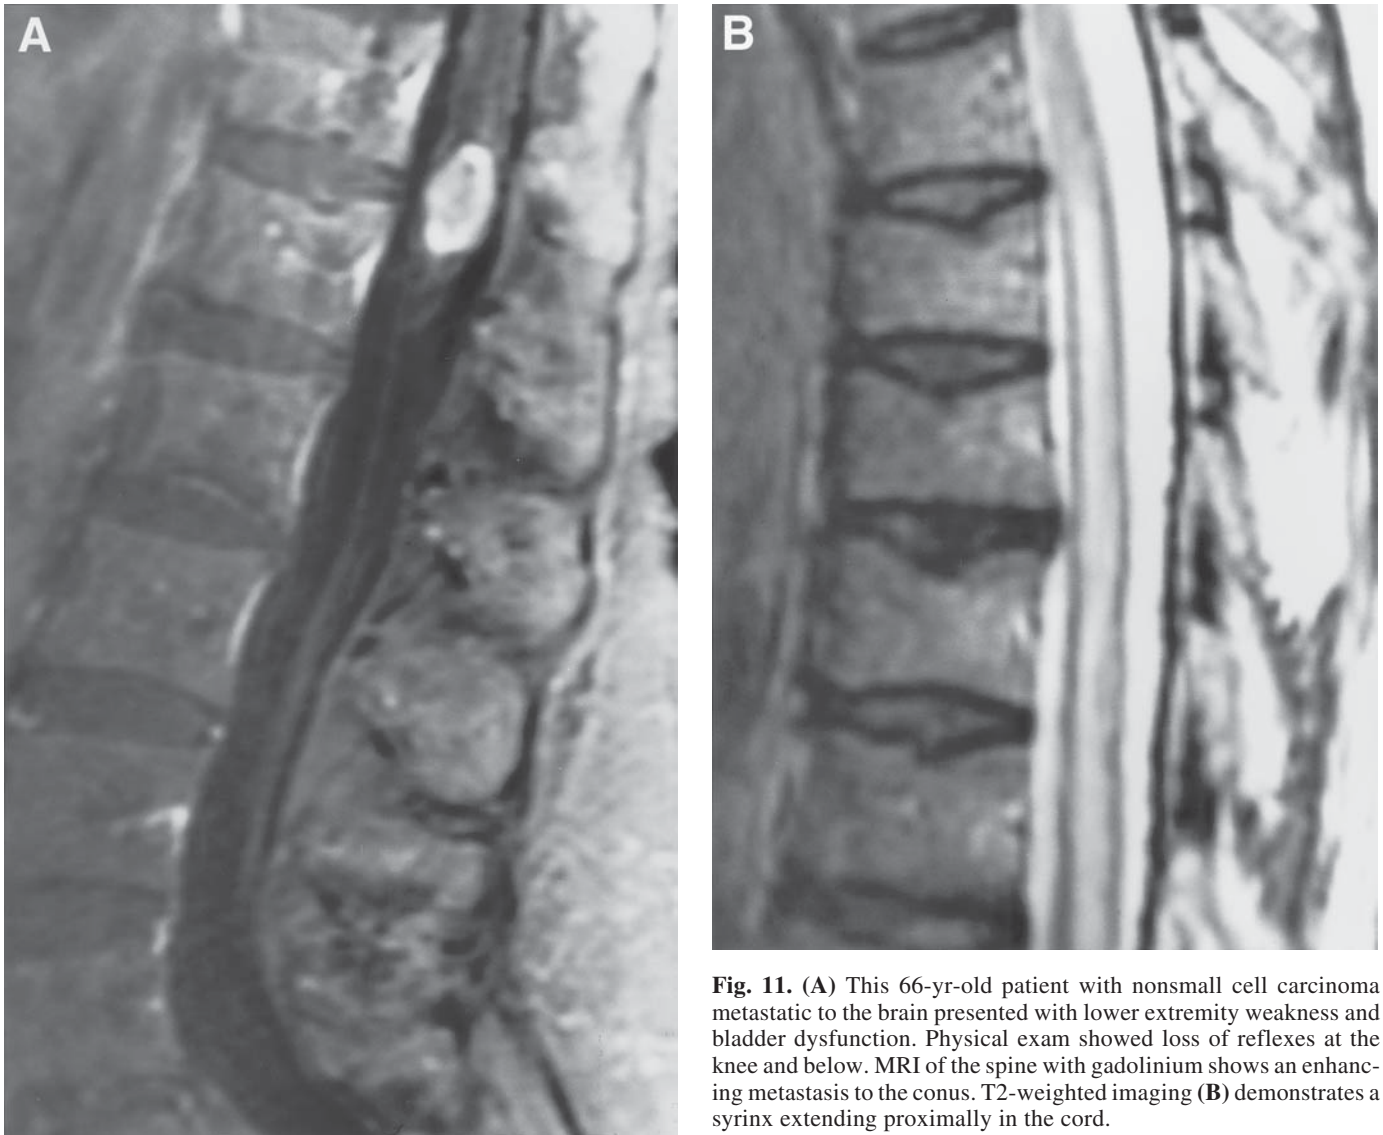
(A) This 66-yr-old patient with nonsmall cell carcinoma metastatic to the brain presented with lower extremity weakness and bladder dysfunction. Physical exam showed loss of reflexes at the knee and below. MRI of the spine with gadolinium shows an enhancing metastasis to the conus. T2-weighted imaging (B) demonstrates a syrinx extending proximally in the cord.
